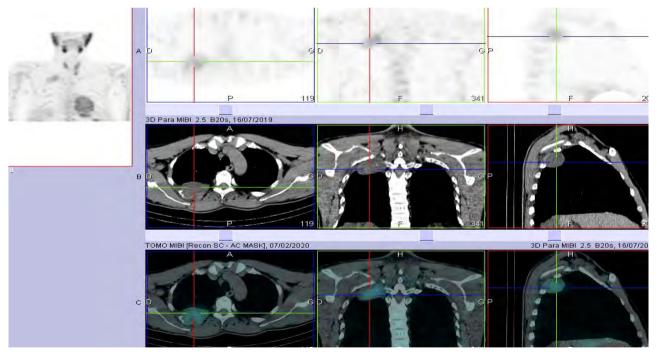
SPECT/CT showing an osteolytic bone lesion of the 4th right rib blowing the cortex, expansive and extended to the adjacent pulmonary field.
